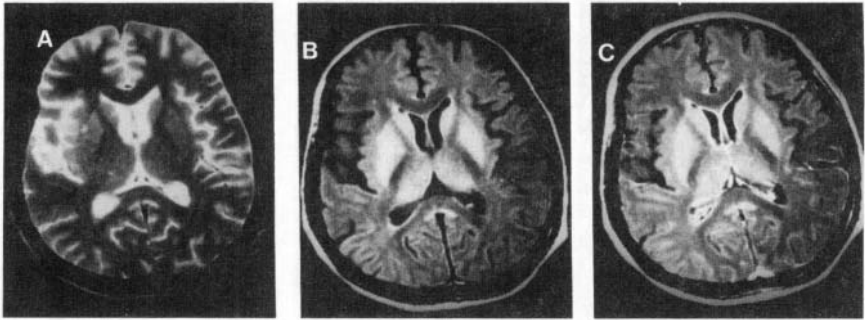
Pyogenic meningitis with ependymitis. T2-weighted axial image (a) at the level of thalami shows no obvious abnormality. T1-weighted MT image (b) shows hyperintense ventricular walls of bilateral frontal and right occipital horn which show enhancement in postcontrast T1-weighted image (c) consistent with ependymitis.
